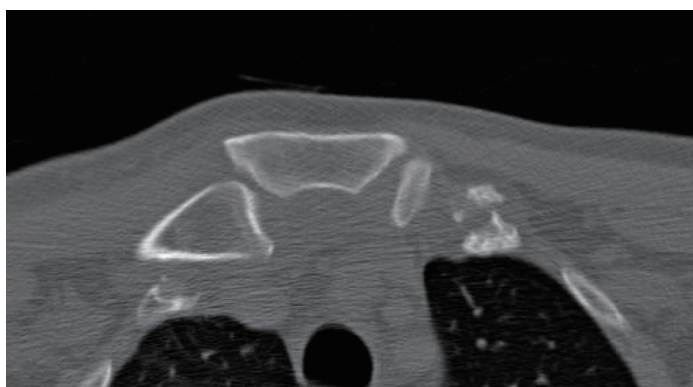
Computed tomography scan showing dislocation of the sternoclavicular joint.
